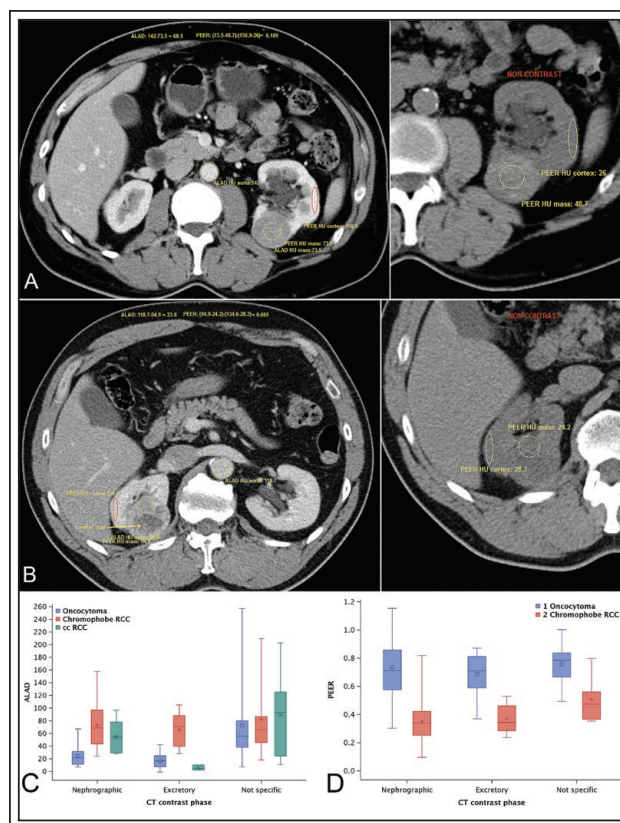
A) Calculation of ALAD and PEER in left renal mass. To calculate the ALAD value, Hounsfield Units (HU) of the aorta and the renal mass were measured on the same plane of CECT. $PEER = (HU_{contrast\ tumor} - HU_{non-contrast\ tumor}) : (HU_{contrast\ cortex} - HU_{non-contrast\ cortex})$. B) Calculation of ALAD and PEER in right renal mass. ALAD and PEER values calculated for right renal mass utilizing the same formula as Figure 1A. C) Distribution of aorta-lesion-attenuation-difference (ALAD) scores by renal mass pathology and CT contrast phase. D) Distribution of peak early-phase enhancement ratio (PEER) scores by renal mass pathology and CT contrast phase.
